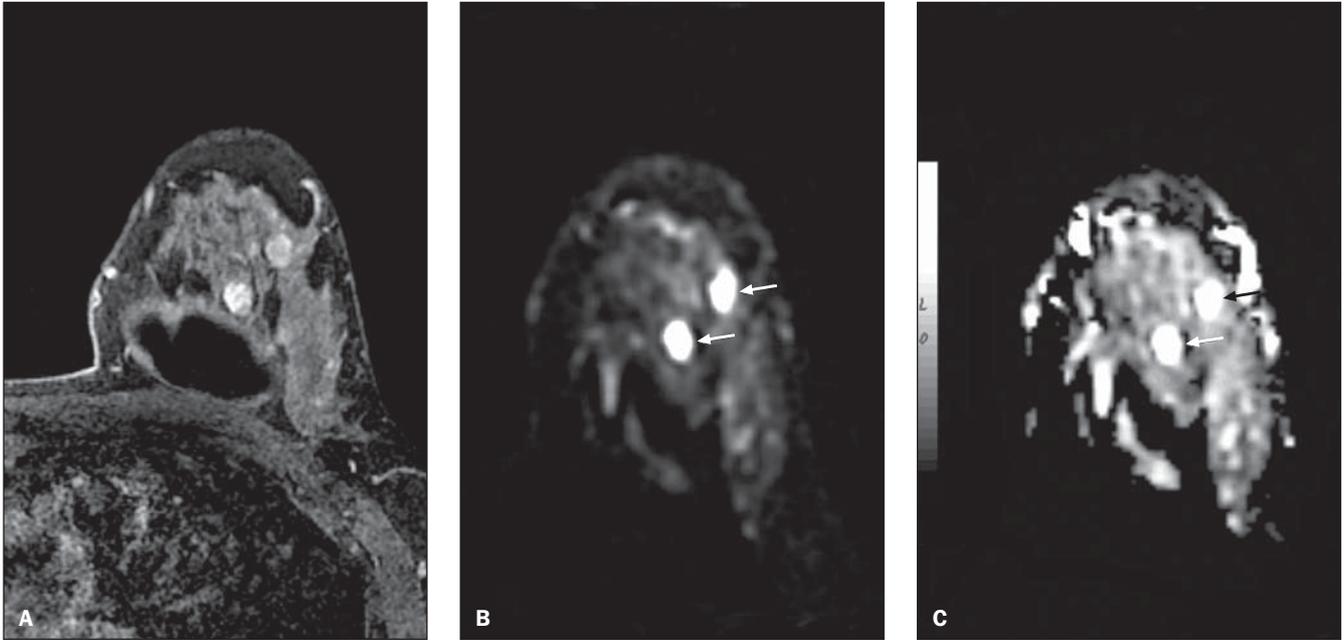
Female, 43-year-old patient presenting fibroadenomas in the left breast. Delayed phase contrast-enhanced 3D gradient, T1-weighted sequence with fat-suppression in the axial plane (A), diffusion-weighted sequence (b 500 s/mm²) in the axial plane (B), and apparent diffusion coefficient (ADC) black/white map in the axial plane (C) show two nodules with morphology and contrast-enhancement with benign appearance. Note that the nodules present high signal intensity on the diffusion (arrows) and on the ADC map (arrows) suggesting absence of water molecules diffusion restriction.
